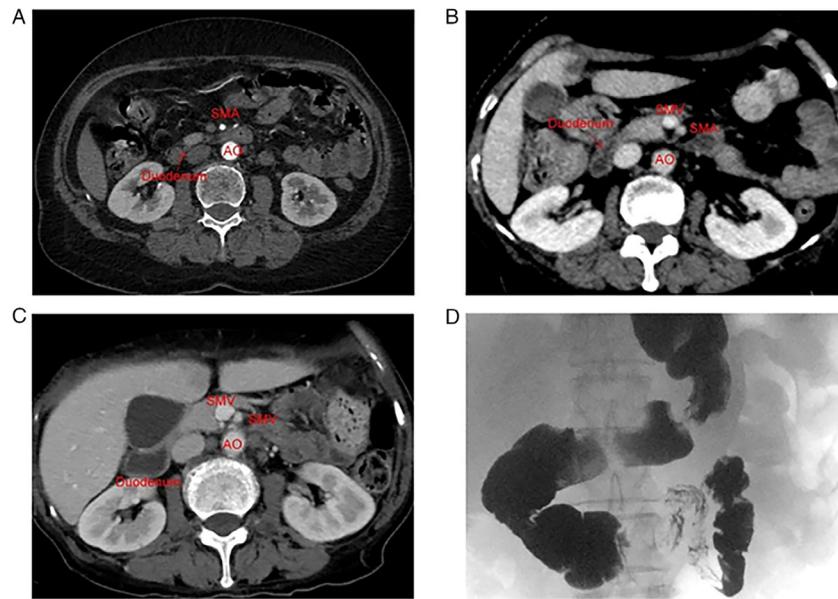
(A) A pre-operative enhanced CT scan of the abdomen indicates no apparent compression in the horizontal section of the duodenum (January 22, 2021). (B) An abdominal contrast-enhanced CT scan indicates beak-like stenosis at the distal end of the duodenum. The distance between the SMA and the abdominal aorta is estimated to be 11.8 mm (March 11, 2021). (C) The enhanced CT scan of the abdomen indicates that the distance between the SMA and the abdominal aorta is reduced further, and the horizontal segment of the duodenum is significantly compressed (May 15, 2021). (D) The barium swallow (upper gastrointestinal series) indicated that the descending part of the duodenum was dilated and longitudinal indentations with smooth and neat edges were noted in the horizontal part (May 15, 2021). CT, computerized tomography; SMA, superior mesenteric artery; SMV, superior mesenteric vein; AO, abdominal aorta.
